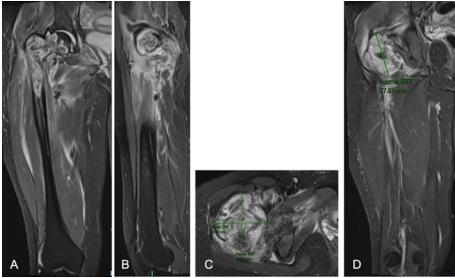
T2-weighted magnetic resonance imaging. (a) coronal, (b) sagittal, C) axial cuts revealing marrow signal abnormality of the right proximal femur with a soft tssue (d) measuring $7.8~\text{cm} \times 6.8~\text{cm} \times 7.8~\text{cm}$ at the level of the neck
